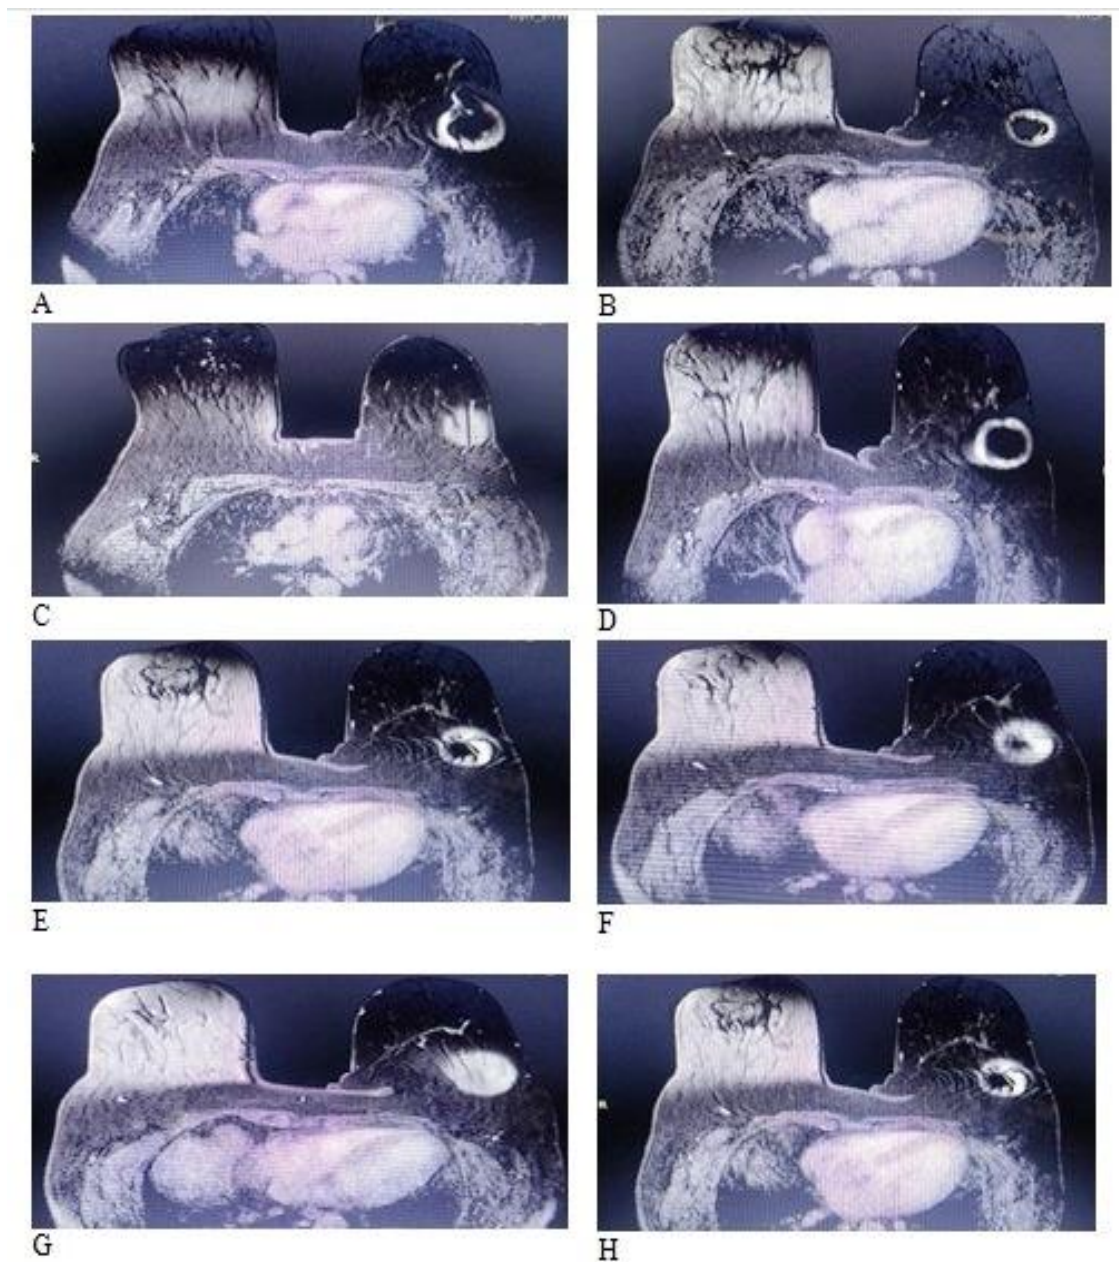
(A, B, C): represent FD MRI showing residual of breast cancer at LT breast.
